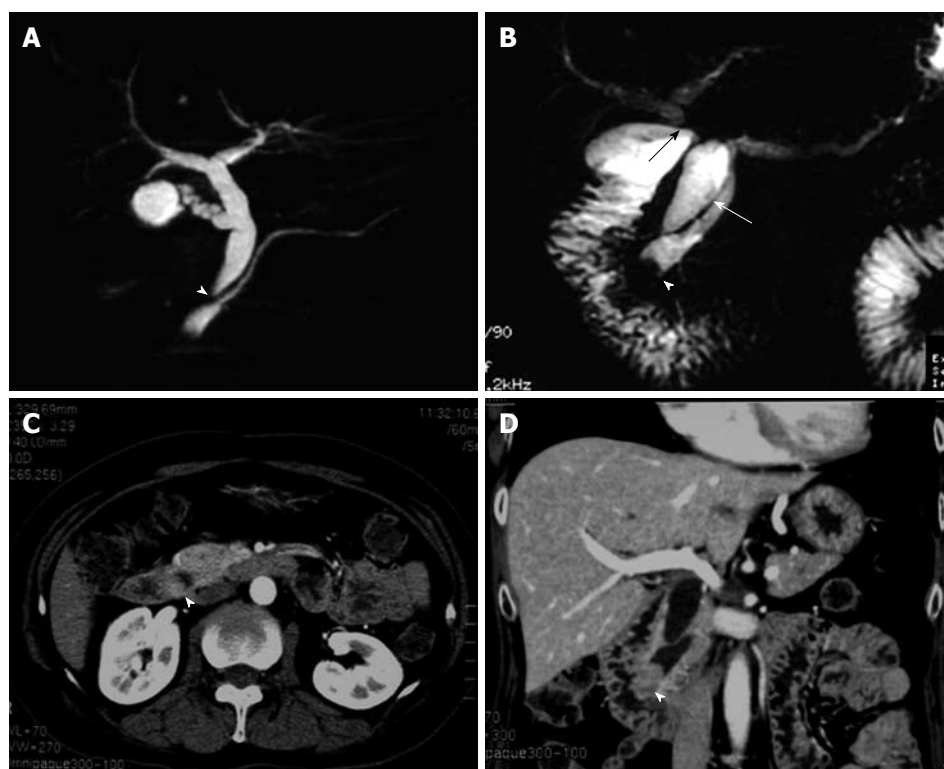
Imaging modalities for pancreaticobiliary maljunction and carcinoma of the papilla of Vater. A: Magnetic resonance cholangiopancreatography before first operation shows both maljunction of the main pancreatic duct and the choledochus (arrowhead) and the choledochal dilation, however there is no finding of neoplasm at the papilla of Vater; B: Magnetic resonance cholangiopancreatography at follow-up after first operation shows the tumor in the main pancreatic duct (arrowhead). In addition, the choledochoduodenostomy (black arrow) and the residual choledochus (white arrow) can be seen; C, D: Computed tomography obtained 2 years after choledochoduodenostomy for pancreaticobiliary maljunction shows the mass in the distal end of the common bile duct, which had not been detected before first operation (arrowheads).
